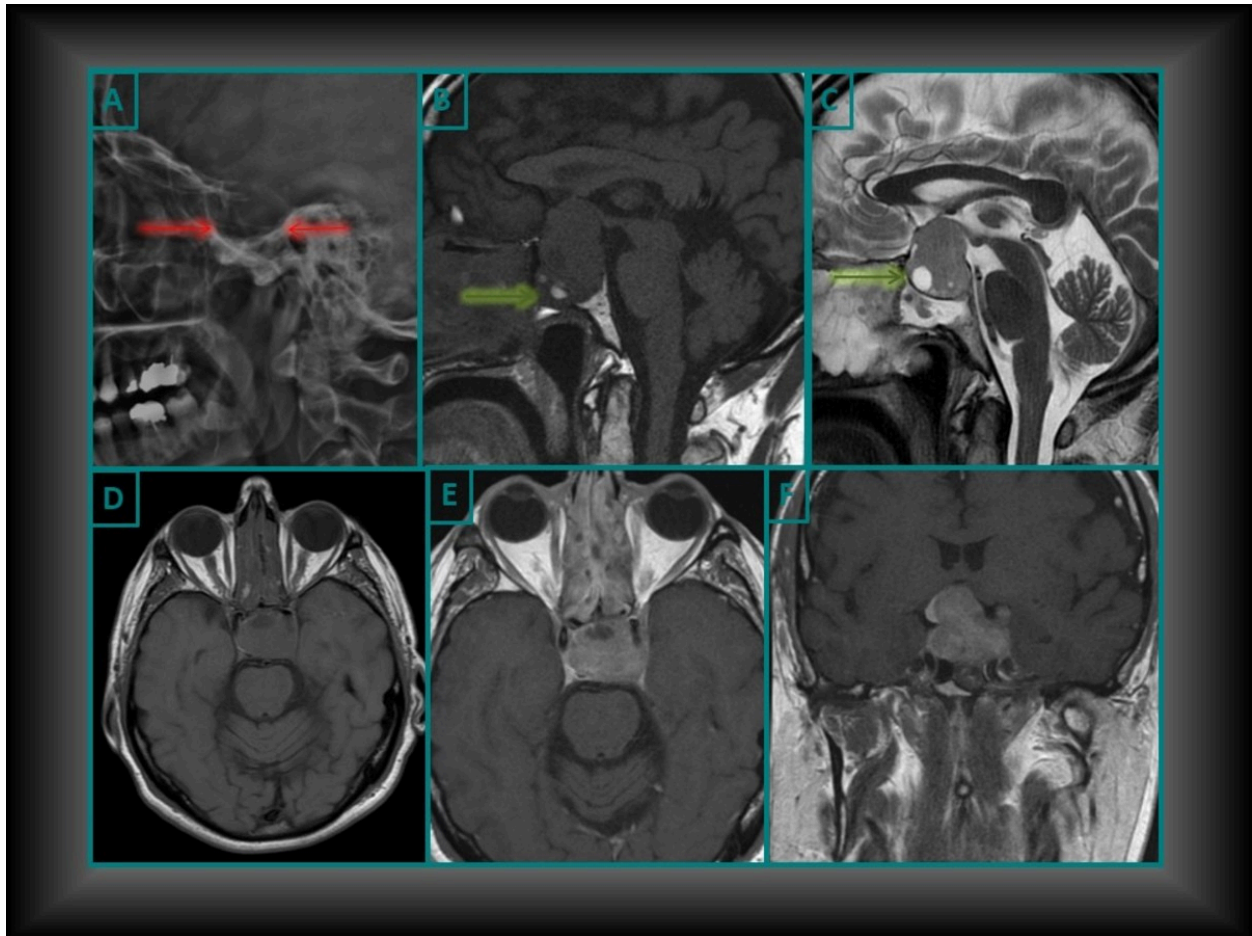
Pituitary Macroadenoma with areas of necrosis or hemorrhage. X-ray (A) reveal the expand the sella turcica (Red arrows), this generally only occurs with pituitary lesions that originate in the sella. Sagittal T1-W (B), Sagittal T2-W (C), Axial T1-W (D) and T1-W-postcontrast (E), Coronal T1-W-postcontrast (F). There is suprasellar extension with elevation and compression of the optic chiasm. They tend to be soft, solid lesions, often with areas of necrosis or hemorrhage as they get bigger (Green arrow). The lesión show intense but heterogeneous enhancement after contrast administration.
